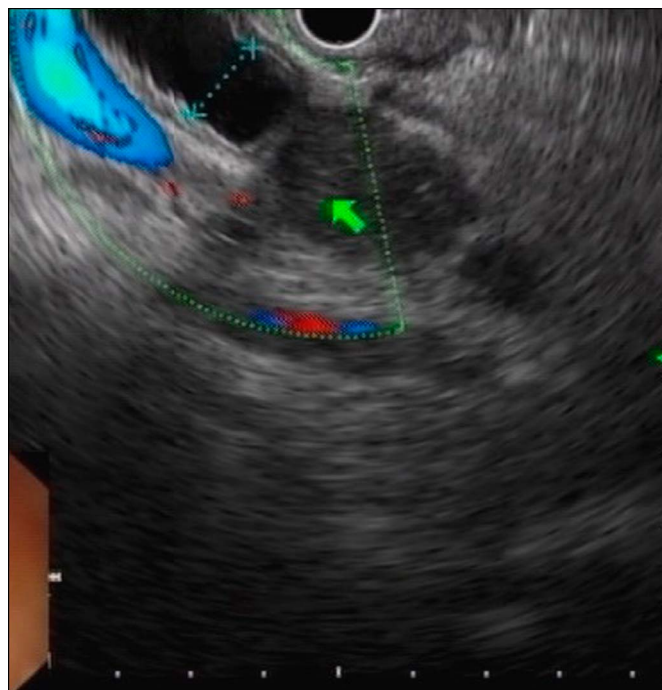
Endoscopic ultrasound showing a hypoechoic lesion involving the distal common bile duct (arrow).
